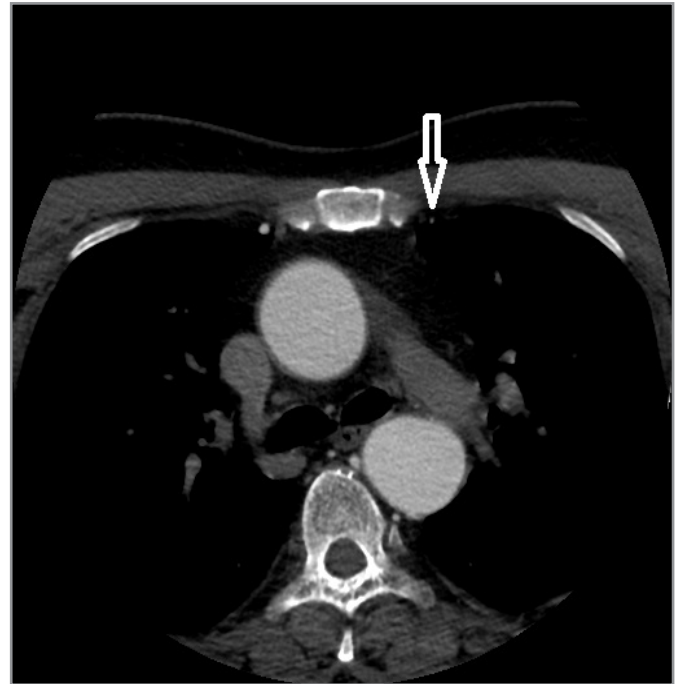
Computed tomography angiography of thorax, axial scan - autobypass from the descending thoracic aorta - white arrow.
